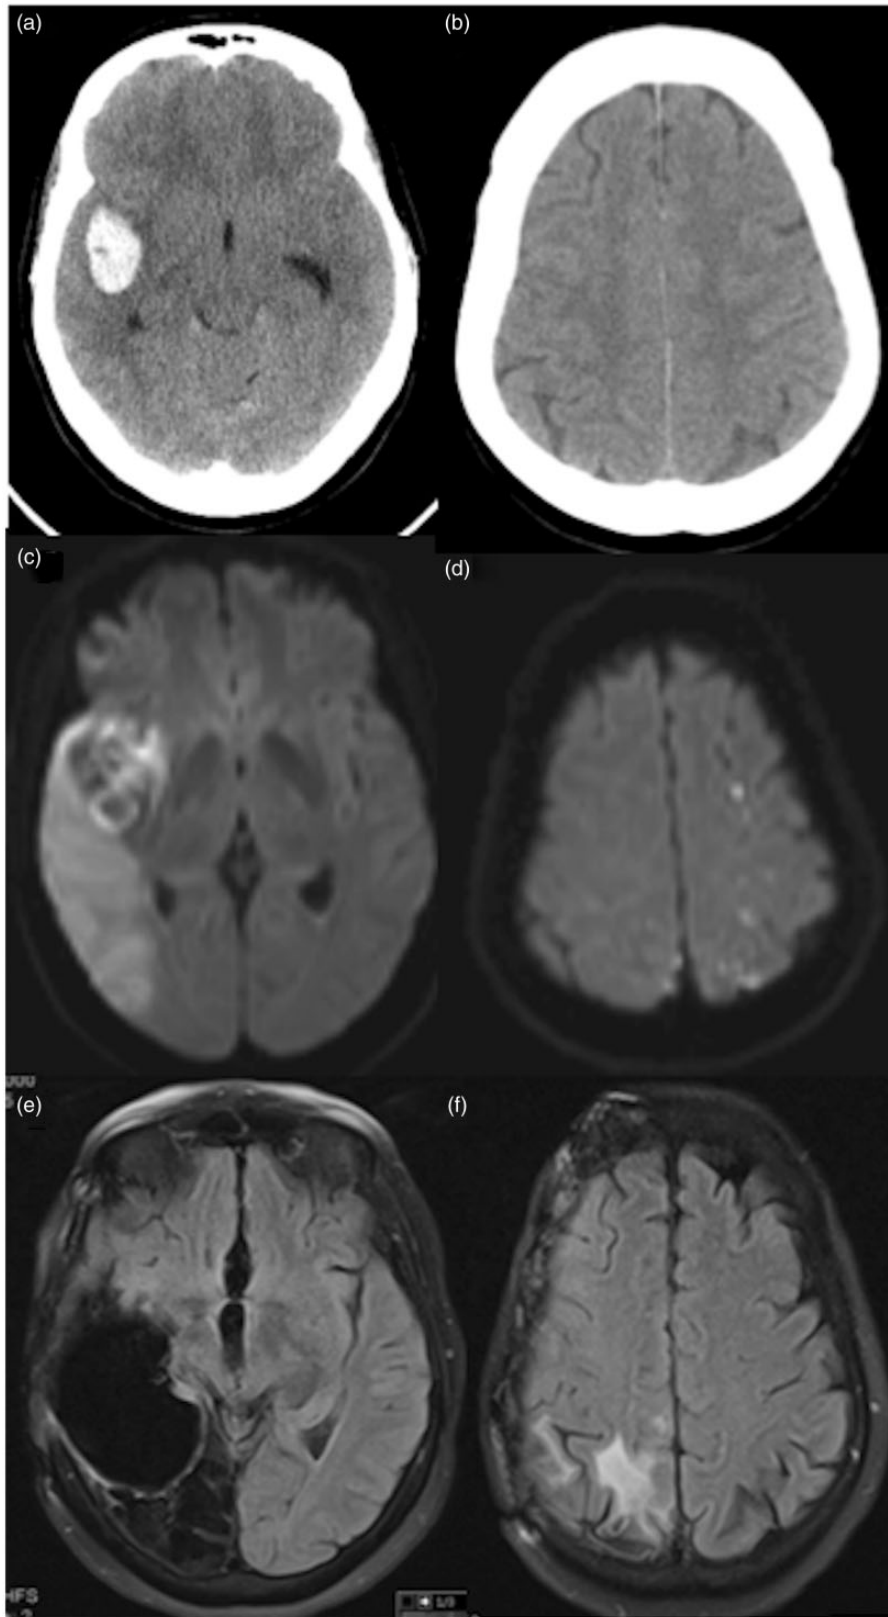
(a, b) Admission CT images of a 50-year old patient with acute SAH and right temporal hematoma, and bilateral middle cerebral artery aneurysms. (c, d) DWI images at 48 h after SAH showing acute ischemic lesions in the right middle cerebral artery territory (c) and watershed infarcts on the left hemisphere (d). MRI performed four years after shows large areas of encephalomalacia on the right temporal and occipital lobes (e), and no evidence of residual left hemispheric lesions (f). The patient had no motor sequelae but was not able to return to her professional activity as a hairdresser and needs constant assistance for daily activities due to severe memory disturbance.
